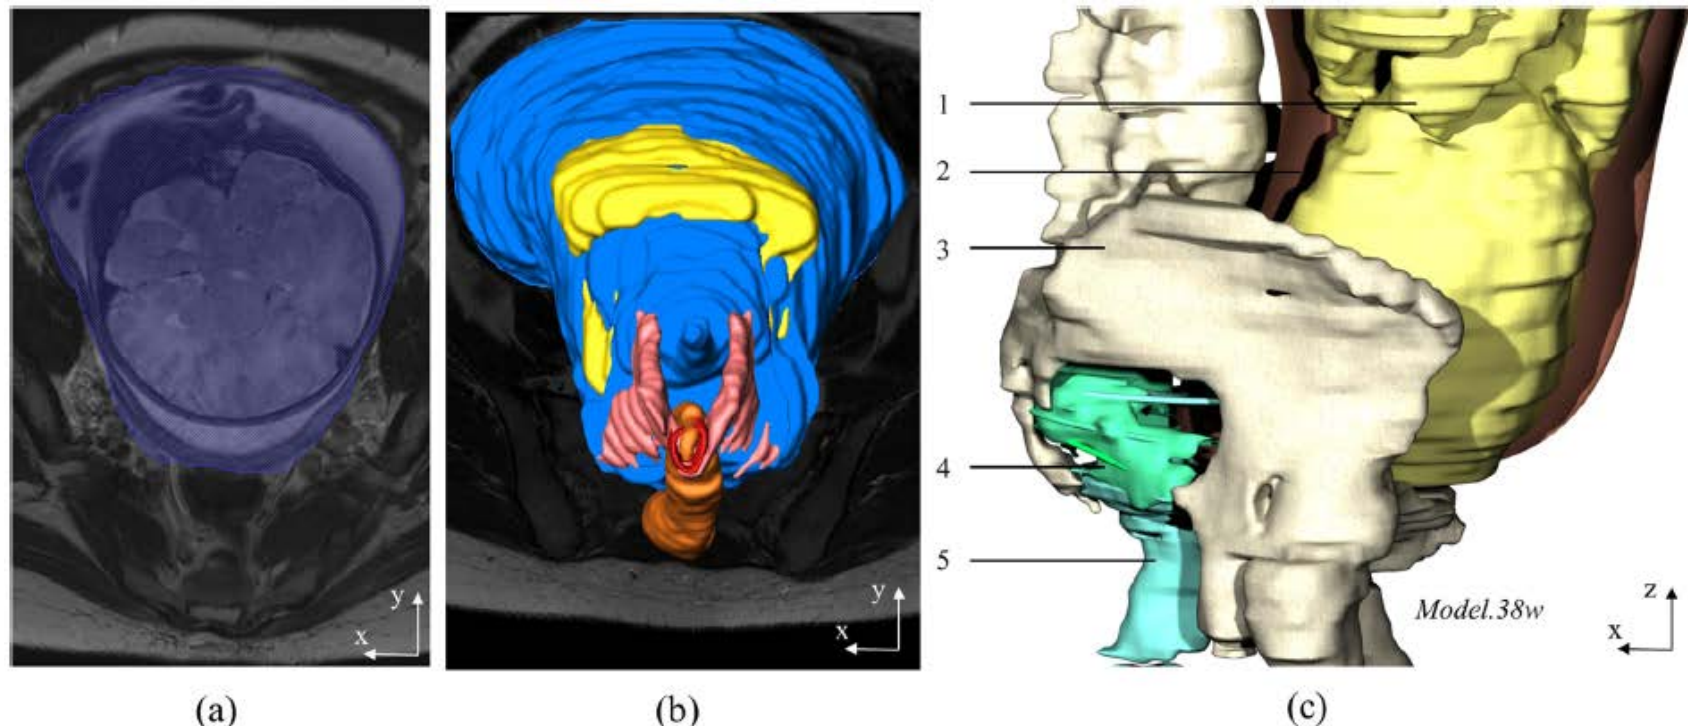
Geometry of the parturient: a Magnetic resonance imaging (MRI) with contour segmentation of the uterus; b 3D reconstruction on the AVIZO software; c 3D model used to analyze geometry: fetus (1), uterus (2), bone (3), uterosacral ligaments (4), puborectal muscle (5)
